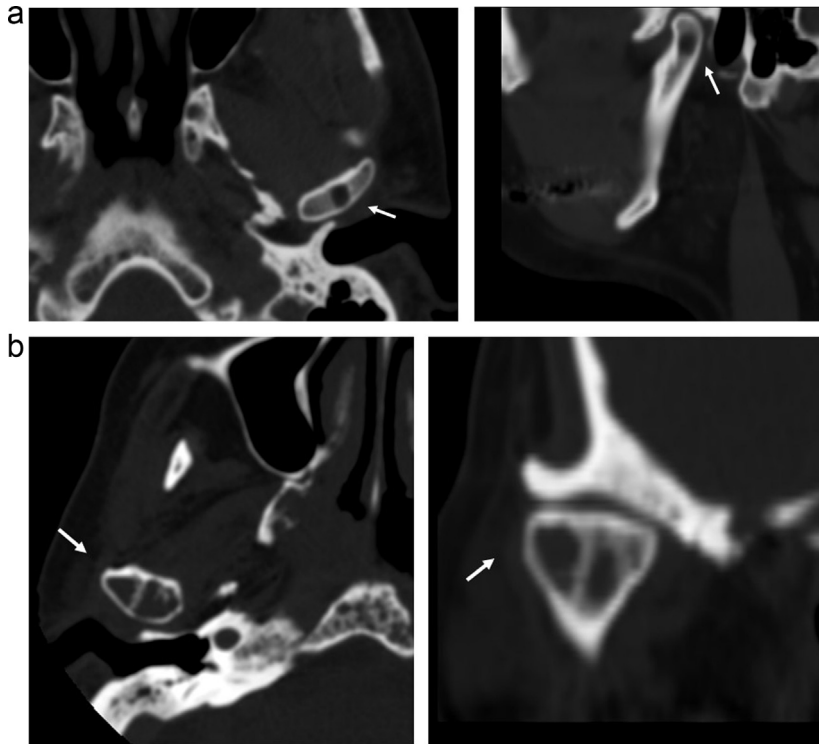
Examples of focal osteolytic lesions (solitary myelomas) involving the condylar head. (A) Axial and sagittal CT scans demonstrating a focal osteolytic lesion (white arrow) of the left condylar head. Note the intact articular cortex and the normal contour of the articular surfaces. The osteolytic lesion lies at a considerable distance from the cortical surface, as opposed to subchondral cysts which lie subjacent to the cortex. (B) Axial and coronal CT scans demonstrating focal osteolytic lesions (white arrow) occupying most of the right condylar head. Although there is significant narrowing of the joint cavity, the articular cortex of the condyle and fossa are intact with no erosions or osteophytes.
